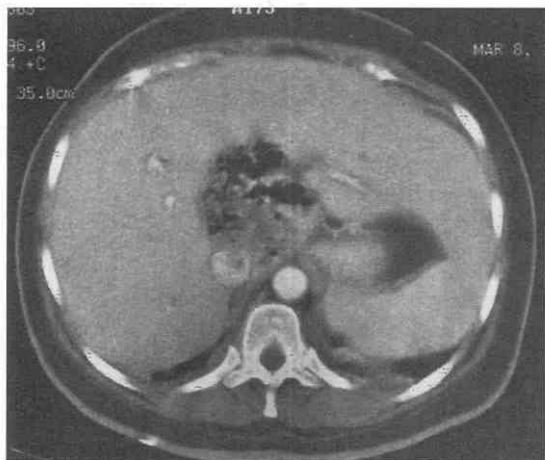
Gram-negative pyogenic abscess of unknown etiology in a 52-year-old woman with diabetes. Contrast-enhanced CT scan demonstrates multiple air-fluid levels in this large central hepatic abscess.
